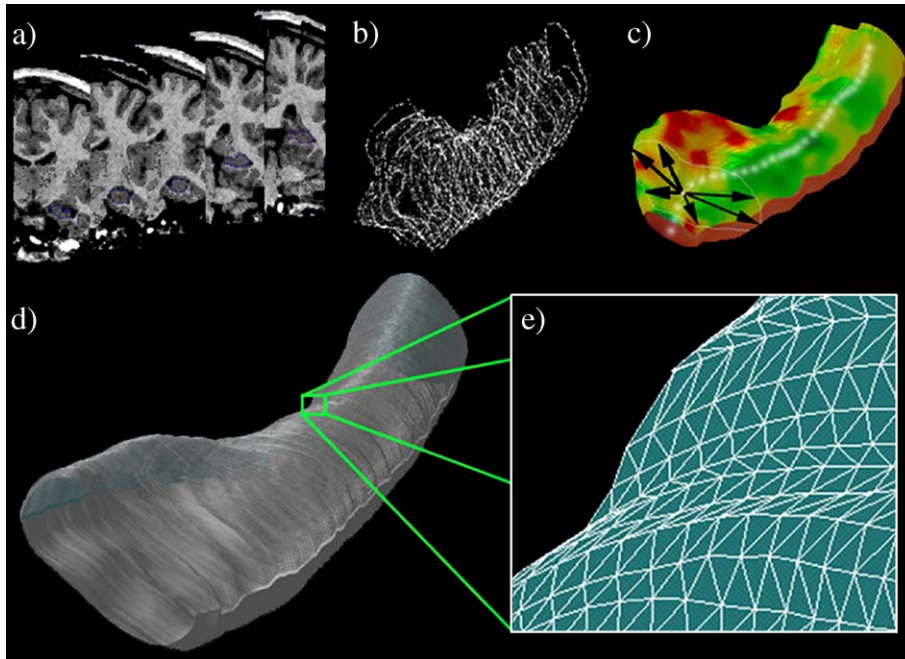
Hippocampal surface modeling. Each individual's hippocampus is traced in coronal MRI sections (a) and converted to a mesh surface representation (b and c) in which the radial size of the hippocampus is measured from a centerline and plotted in color on the surface to index radial atrophy. Arrows in (c) represent vectors from the centerline to various points on the hippocampal surface. These meshes are averaged across subjects (d), and atrophy or expansion relative to the control mean is computed at each surface point (e).
